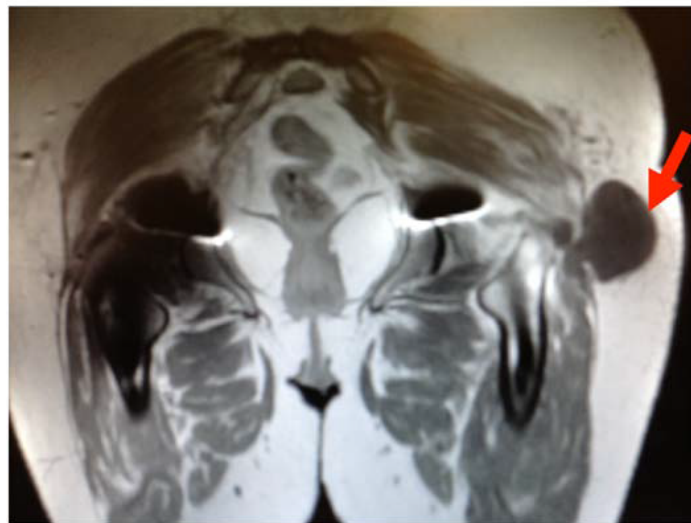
Magnetic resonance image depicting a pseudotumour (arrow) adjacent to a MoM hip prosthesis originating from the abductor muscle†.
